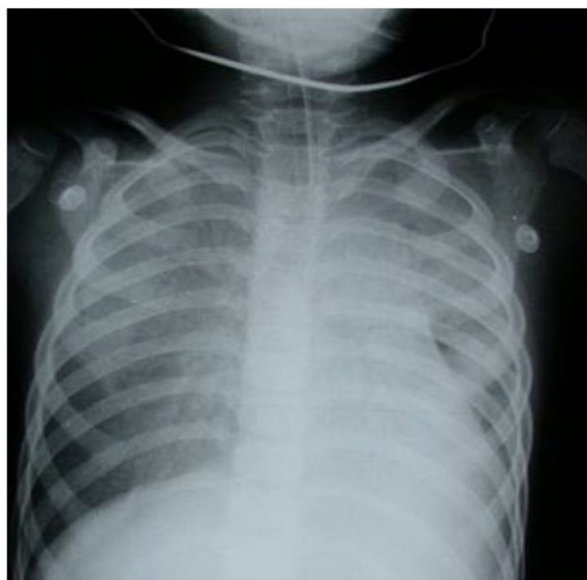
X-Ray chest showing features of ARDS.
